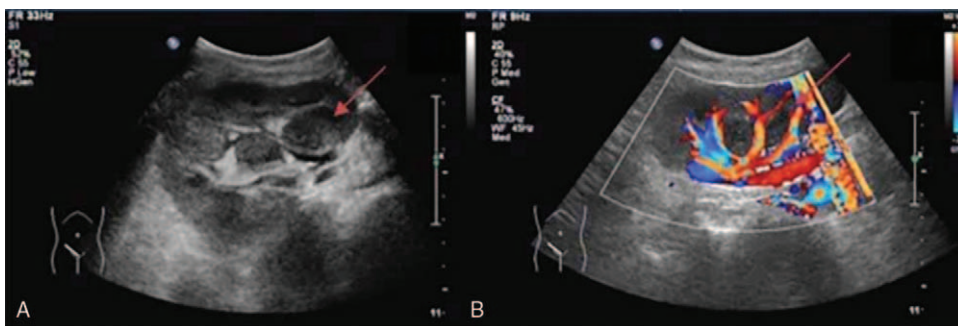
Ultrasonography (A) and color Doppler ultrasound (B) depicted 2 hypoechoic masses located in the hilum, with no evidence of infiltration or an effect on surrounding blood vessels. CDUS=color Doppler ultrasound, US=ultrasonography.
